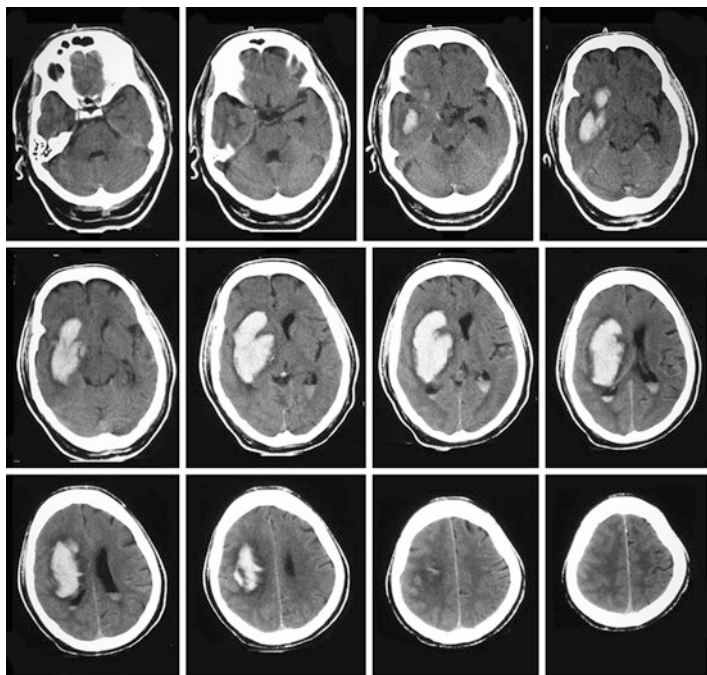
Non-contrast CT scan of a 60-year-old male who developed sudden left hemiplegia and headache but was alert and orientated. It shows a large left internal capsular hemorrhage which has ruptured into the ventricles. Note that, in spite of the size of the intracerebral hematoma there is very little SAH. Compare with Fig. 3.14 which is aneurysmal SAH with an intracerebral hematoma
